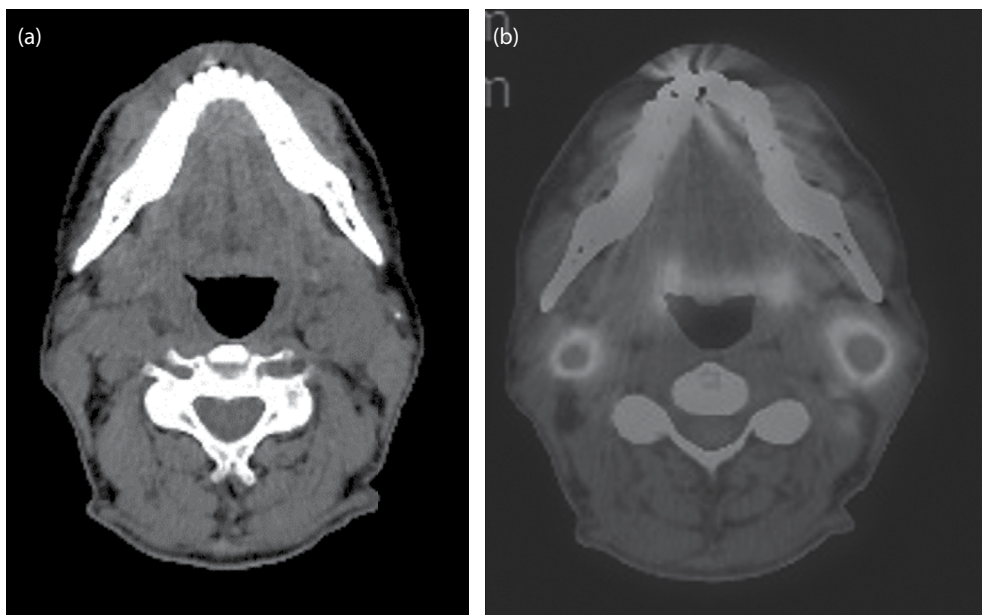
(a) CT and (b) PET-CT fused with PET avid nodes in supraglottic SCC.
